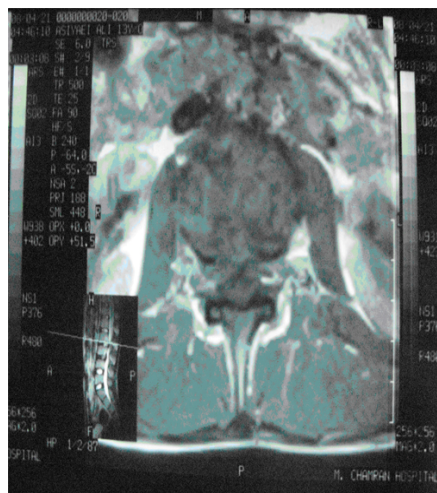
MRI (axial view) from L2-L3 inter vertebral disc.
